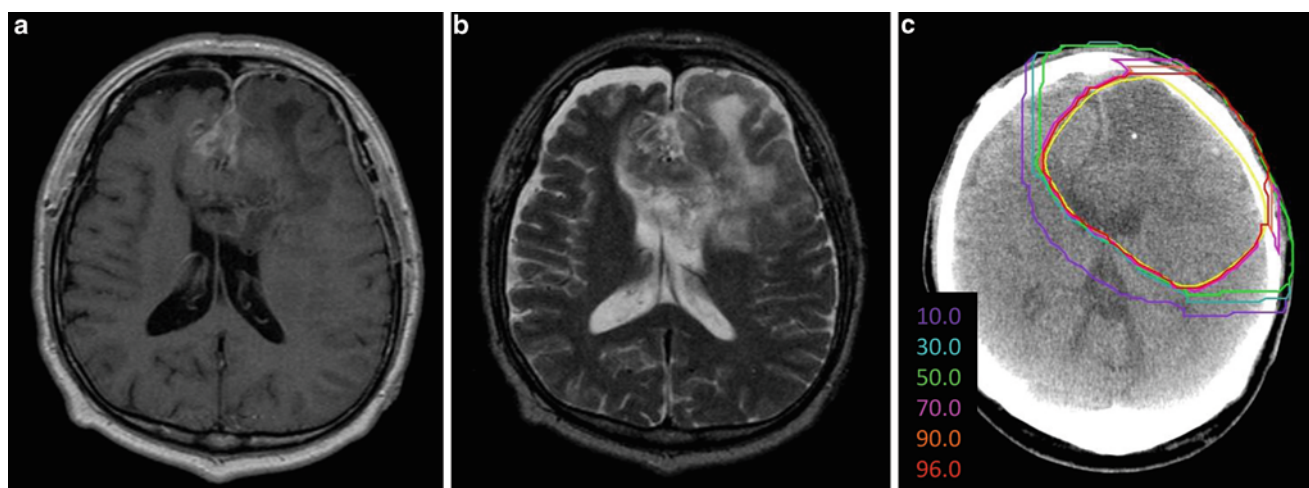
(a) T2-weighted MRI and (b) gadolinium-enhanced T1-weighted MRI obtained before C-ion RT. (c) Representative axial isodose distributions at the level of lateral ventricle
